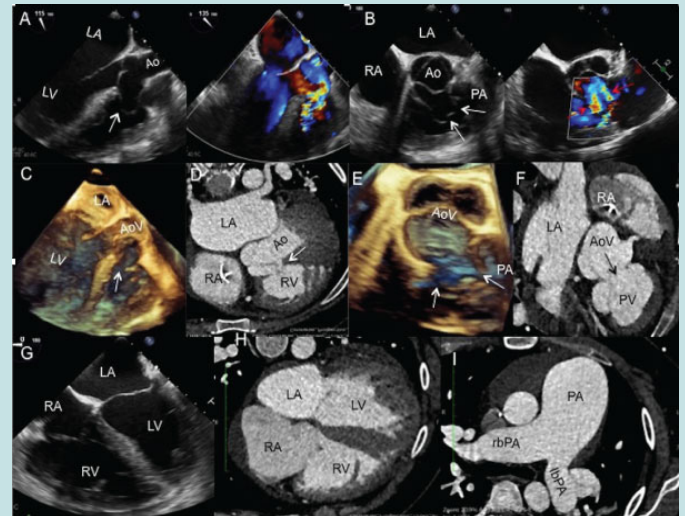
A-Transesophageal two-dimensional and color-flow echocardiogram, showing the rupture of the right coronary sinus aneurysm into the right ventricle (white arrow) B- above the pulmonary valve (white arrow). A mild pulmonary regurgitation is also observed. C- three-dimensional transesophageal echocardiography at 135° and computed tomography (D), pointing the rupture into the right ventricle (white arrow). E- three-dimensional transesophageal echocardiogram at 50° with rupture of the right coronary sinus into the right ventricle (white arrow) and above pulmonary valve (white arrow) and F- into the pulmonary valve visualized in the computed tomography (black arrow). G- two-dimensional transesophageal echocardiogram at 0°, and H, I- computed tomography, showing dilation of the right cavities and of the trunk and branches of the pulmonary artery.
